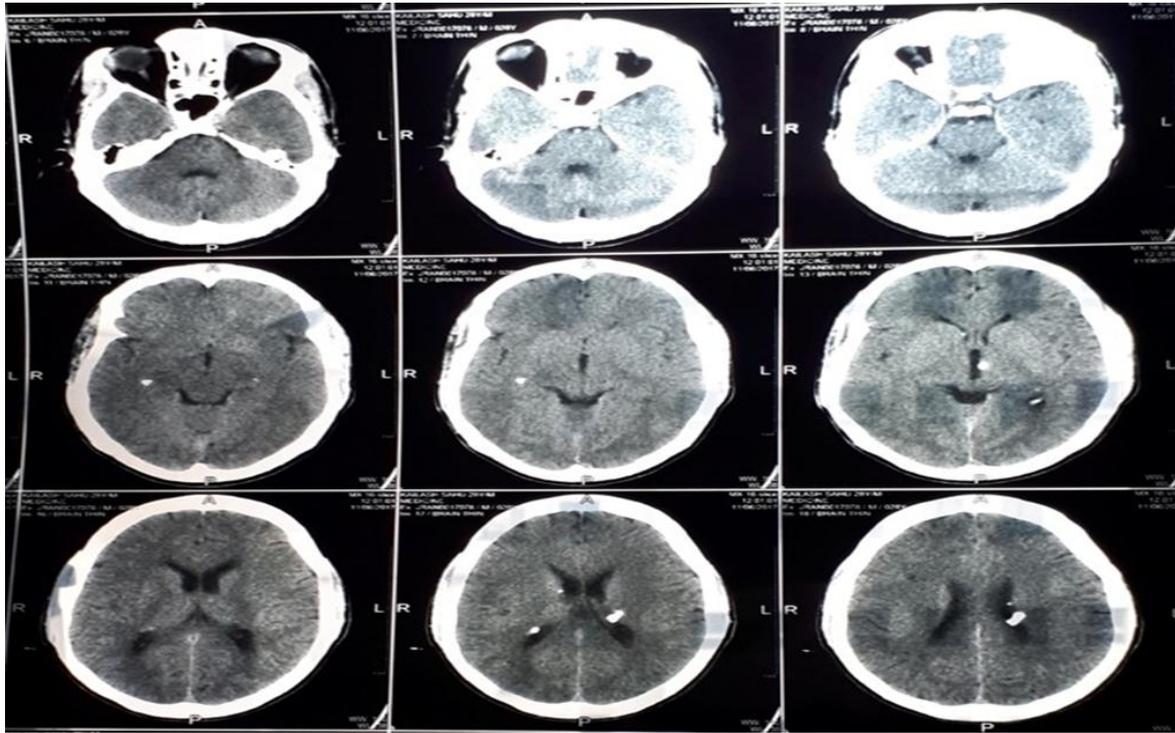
CT Brain showing subependymal nodules (Case 1)
